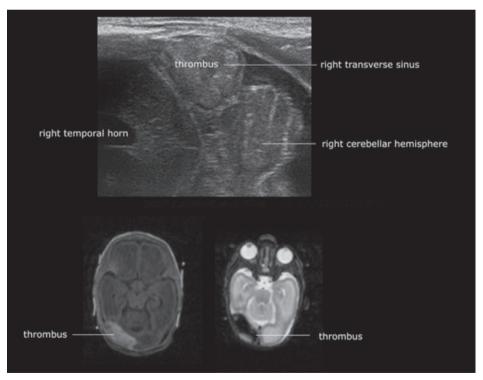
Top image: an overview through the mastoid fontanel showing a thrombus in the right transverse sinus. Below right: T1 weighted MR image, showing hypersignal intensity of the thrombus, and below
